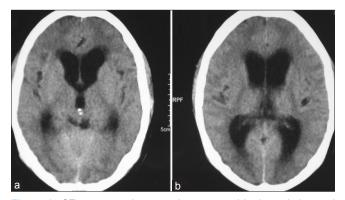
CT scan on admission demonstrated hydrocephalus and peri-ventricular ooze
